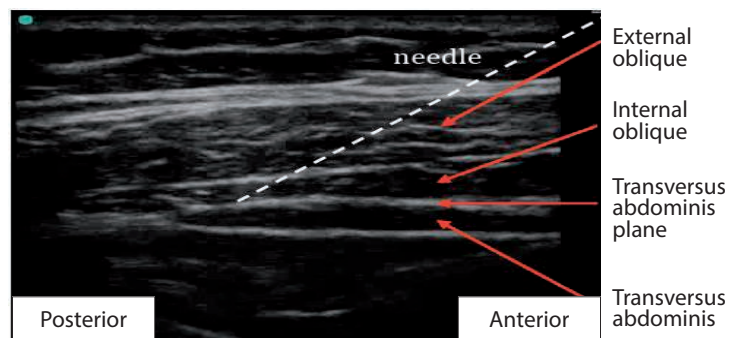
Ultrasound image during posterior TAP Block. The transversus abdominis muscle can be seen to taper into a fascial line. The approximate needle insertion angle is indicated.
